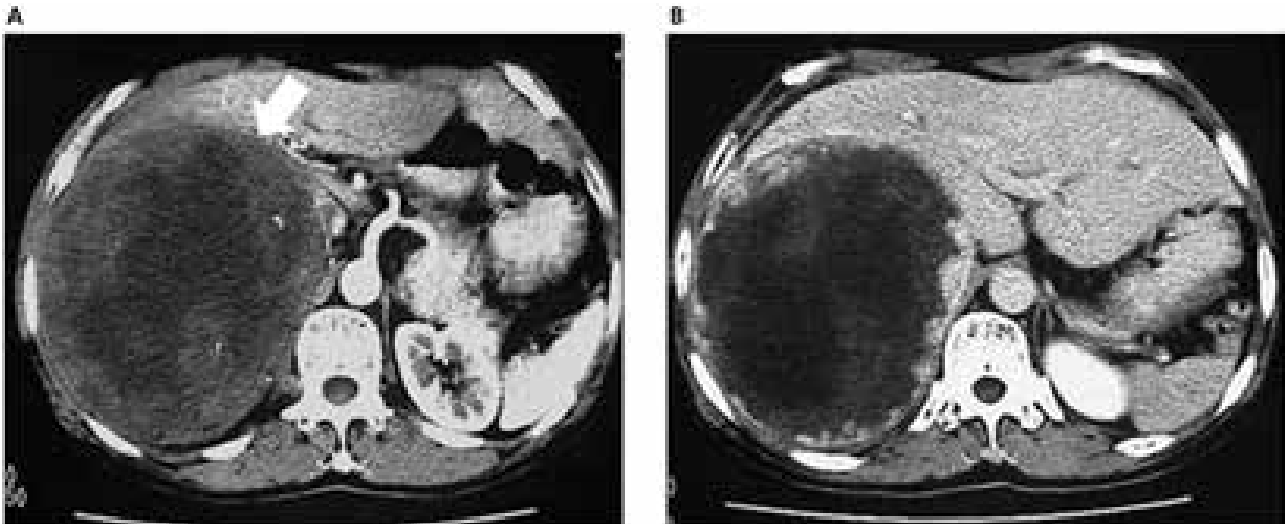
On axial DCE-CT, slight irregular peripheral enhancement and small calcifications during the arterial phase and more intense peripheral enhancement during the delayed phase within a mass (arrow) suggests a cavernous hemangioma of the right adrenal gland. (Xu HX, Liu GJ. Huge cavernous hemangioma of the adrenal gland. *J Ultrasound Med* 2003; 22: 523-526)
